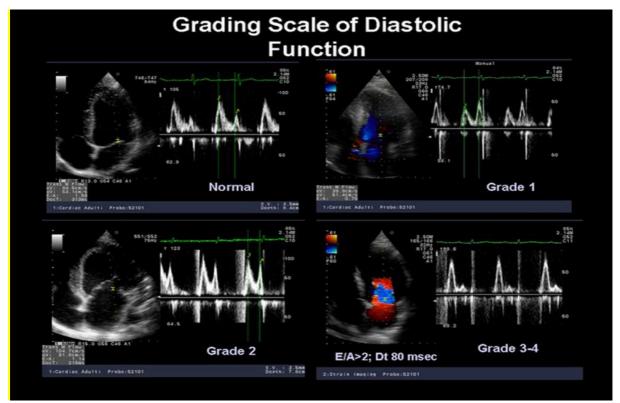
Echocardiographic classification of diastolic dysfunction.Adapted with permission from the American Medical Association.(Adapted from Redfield et al., 2003.)
